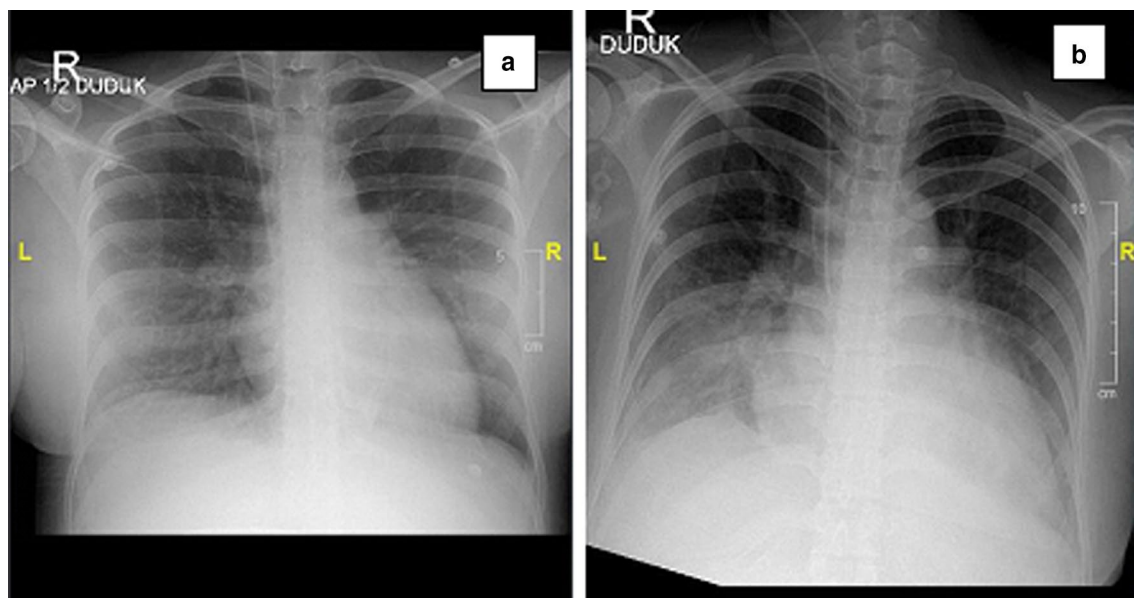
Thorax X-ray during the third day a compared to the seventh day b showed progression from pulmonary hypertension to cardiomegaly and pulmonary edema
